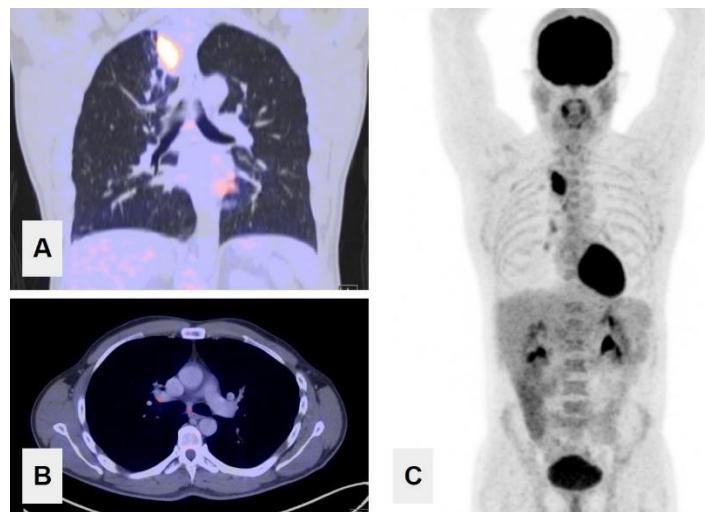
Pet-scan showing increased SUV in already known mass in right upper lung vertex (SUV 10) (A, C) and mediastinal and right hilar subcentimeter lymph nodes (SUV 2.8 and 3.9) (B). No other organs with pathological findings were evidenced by this method.
